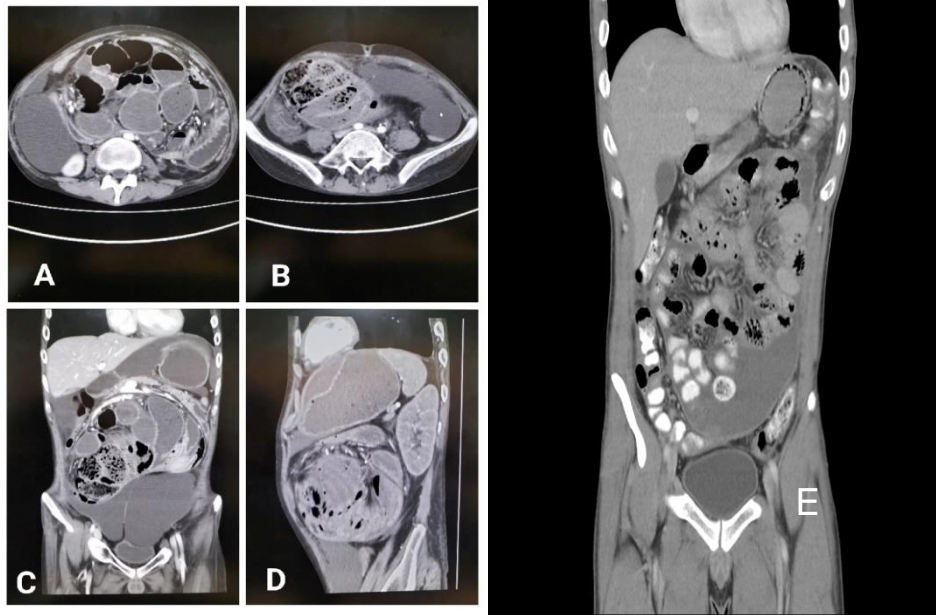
Figure A & D shows abnormal dilated small bowel loops showing air fluid levels which are encased by enhancing membrane. Figure B shows fecalization of small bowel loops. Figure C shows enhancing peritoneum and localized multiseptated fluid collection. Figure E: A coronal section of CT scan Abdomen showing cocooning of the intestinal loops.
